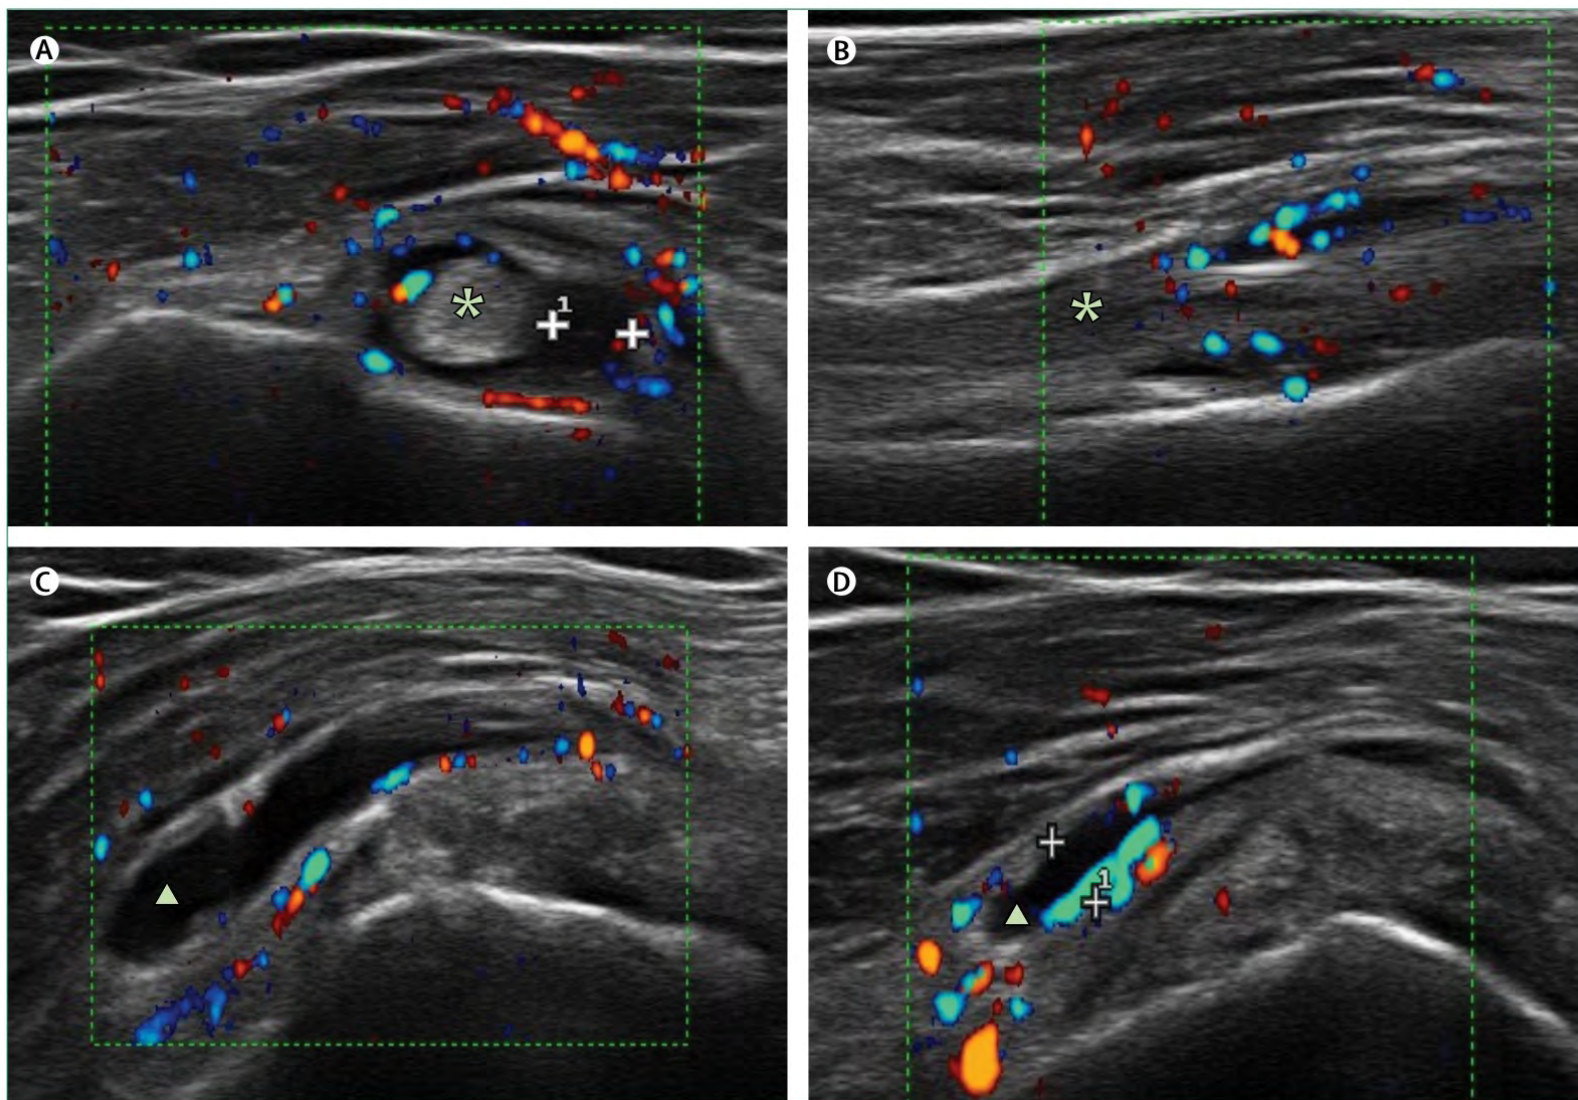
Ultrasonography of the shoulders in a patient with polymyalgia rheumatica
